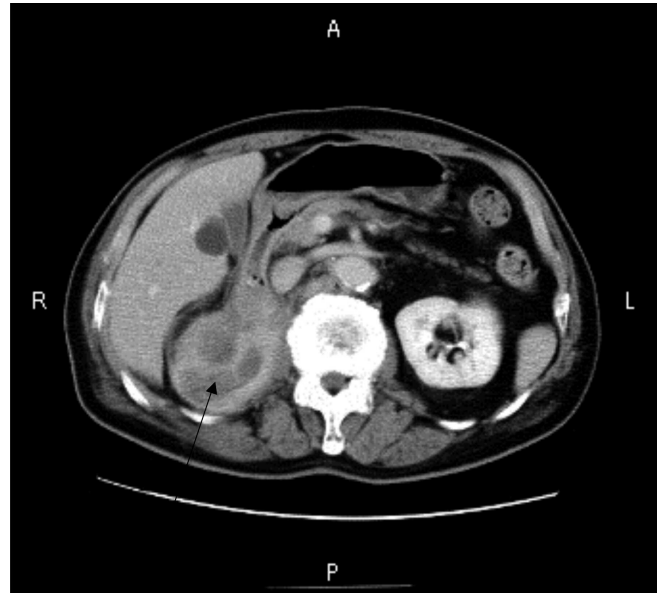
CT finding of the retroperitoneal tumor (arrow). The tumor is large.
